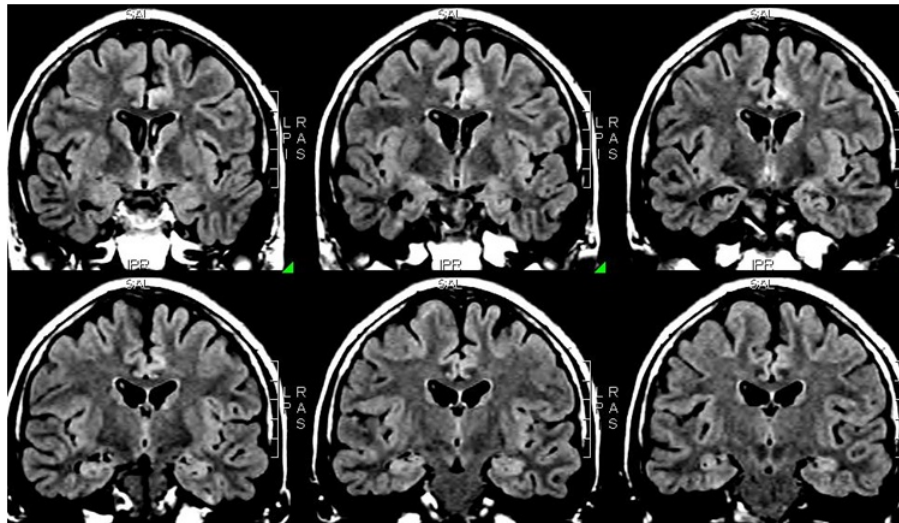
MRI (coronal section) of eTLE patient.
